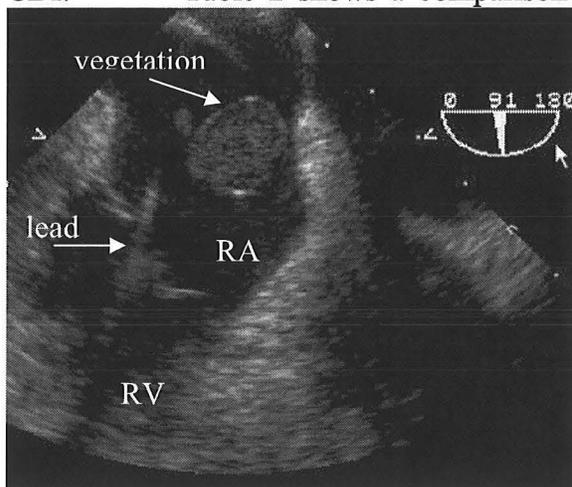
Transesophageal echocardiogram of a pacemaker vegetation.
